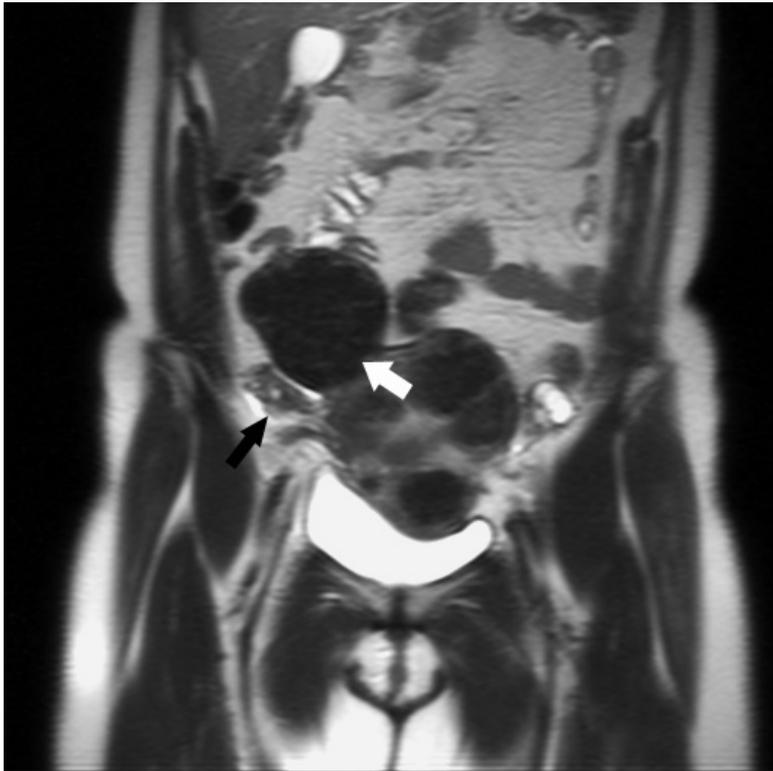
MRI of leiomyoma – locations. T2-weighted coronal image of a polyfibroid uterus. A subserosal pedunculated uterine fibroid (*white arrow*) is easily identified by its low signal intensity and continuity with the right lateral aspect of the uterine fundus while sonographically the lesion could not be separated from the right ovary (*black arrow*). (Reproduced with permission from [223])
